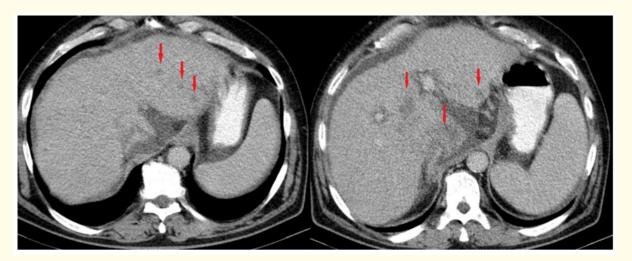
abdominal CT: venous phase: nodular lesions with low contrast enhancement (red arrows).
